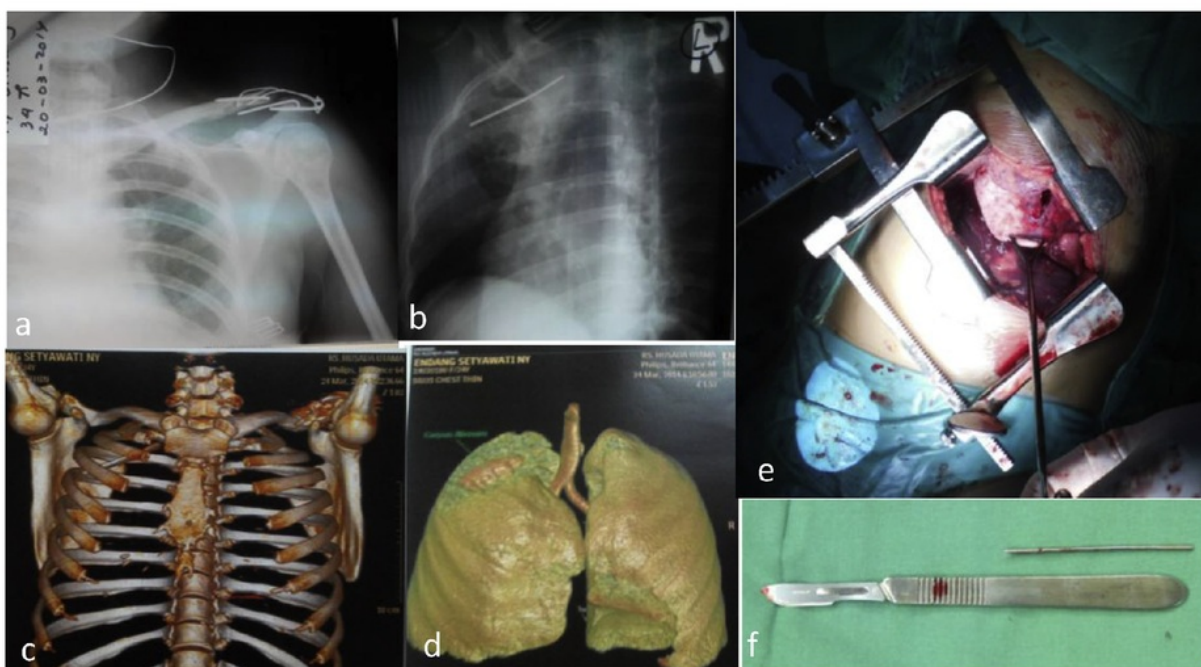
Trans thoracal migration of K-wire. (a) Tension Band Wire after 1 year (b) X Ray picture one K wire migrate to the right lung (c) CT Scan show location of K wire in right thorax (d) MRI showed K wire in the right lung (e) K-wire in lung parenchym (f). Length of K-wire after removal.
